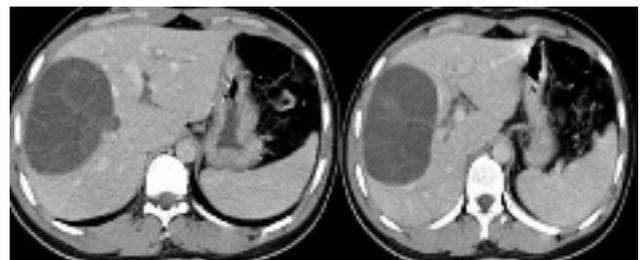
CT scan image showing a huge multisegmented hydatid cyst of the right lobe occupying the segments V, VII, and VIII. The intrahepatic biliary trees of around the cysts lesion were dilated
